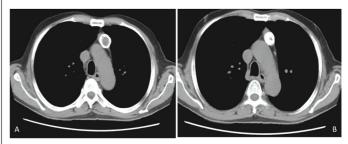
CT Thorax-Mediastinal window showing (A) cystic shadow with calcified curvilinear border in the anterior mediastinum and (B) dense calcified lesion in the anterior mediastinum with central necrosis.
